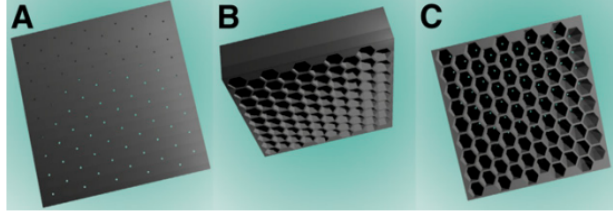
BiCore collimator used in the Siemens Symbia T6 SPECT system shown from the A) face, B) side, and C) back of the collimator. Note: Image from “A Parallel-Cone Collimator for High-Energy SPECT” by C. Beijst et al., 2015, *Journal of Nuclear Medicine*, 56(3), pp. 476-482.
